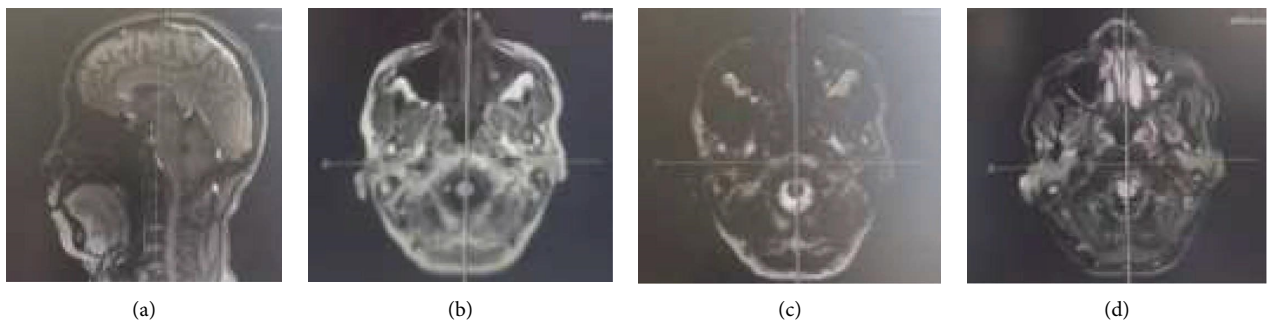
MRI image data of a patient. Female, 58 years old, high tinnitus in both ears without obvious inducement, followed by hearing loss, and gradually aggravated, with basic hearing loss in the recent six months, unstable walking, and tremor on both upper limbs. (a) MRI sagittal image; (b–c) T1 weighted image; and (d) T2 weighted image.
